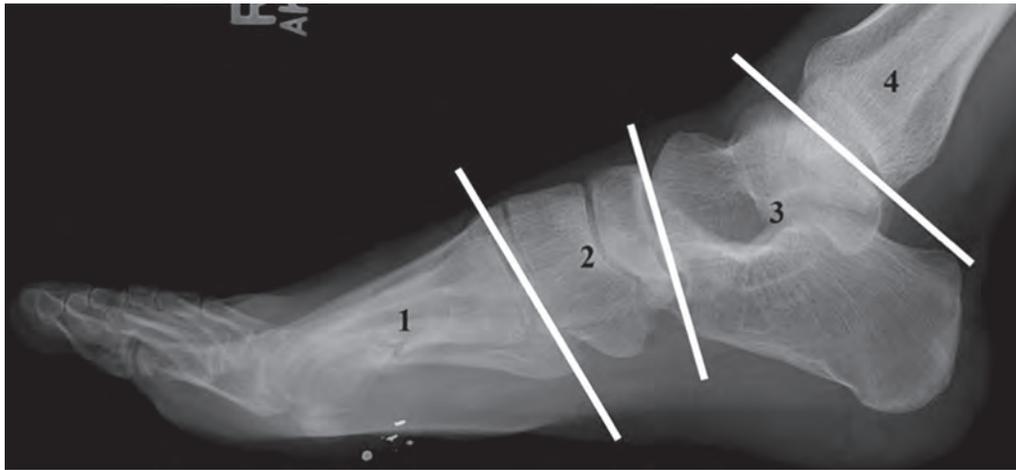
Lateral radiographic view of the zones of injury. 1: distal to the tarsometatarsal joint, including the metatarsals and phalanges. This radiograph shows an example of a zone one injury. Two: between the transverse tarsal joint and the tarsometatarsal joint, including the cuneiforms, navicular, and cuboid. Three: hindfoot with the talus and calcaneus. Four: ankle joint and proximal, including the distal tibia and distal fibula.
